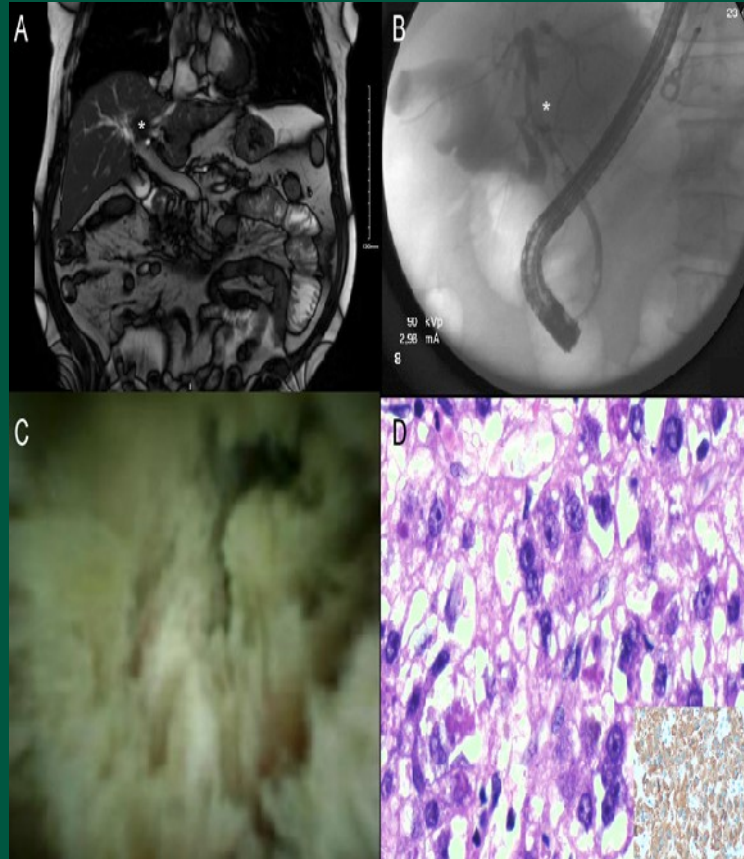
MRI image with mass (marked with *)
